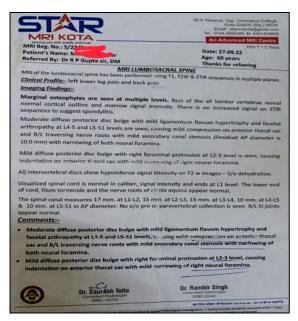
MRI Lumbarsacral spine
